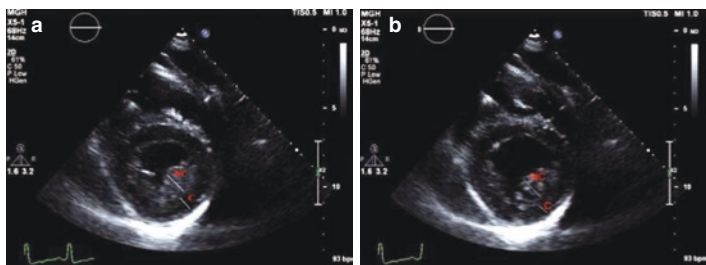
Short axis on a transthoracic echocardiogram of a patient with LV non-compaction in (a) systole and in (b) diastole. Two distinct layers of myocardium are seen. C is a compacted layer and NC is a non-compacted layer. A ratio of $>2:1$ in systole is required for the diagnosis of LV non-compaction by Jenni criteria
